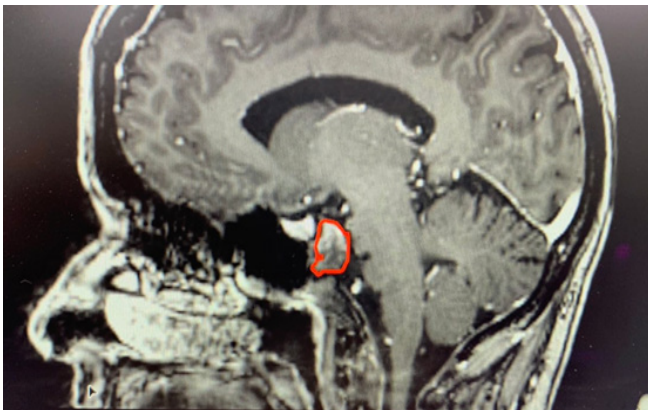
Magnetic Resonance Imaging (MRI) in sagittal section revealing the tumor.
